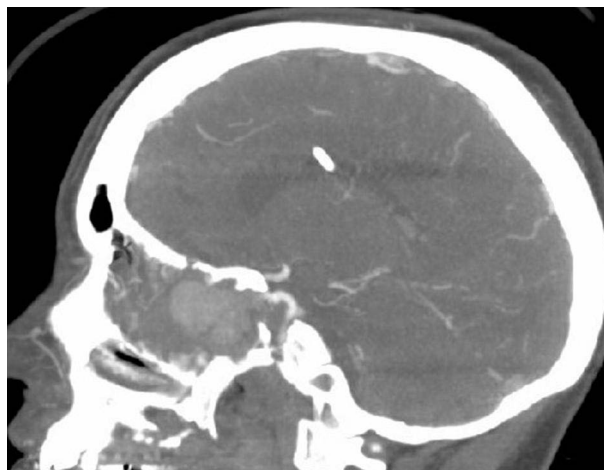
Sagittal view of the head CT with contrast showing a pseudoaneurysm of the cavernous portion of the right internal carotid artery protruding into the ethmoidal sinus.
